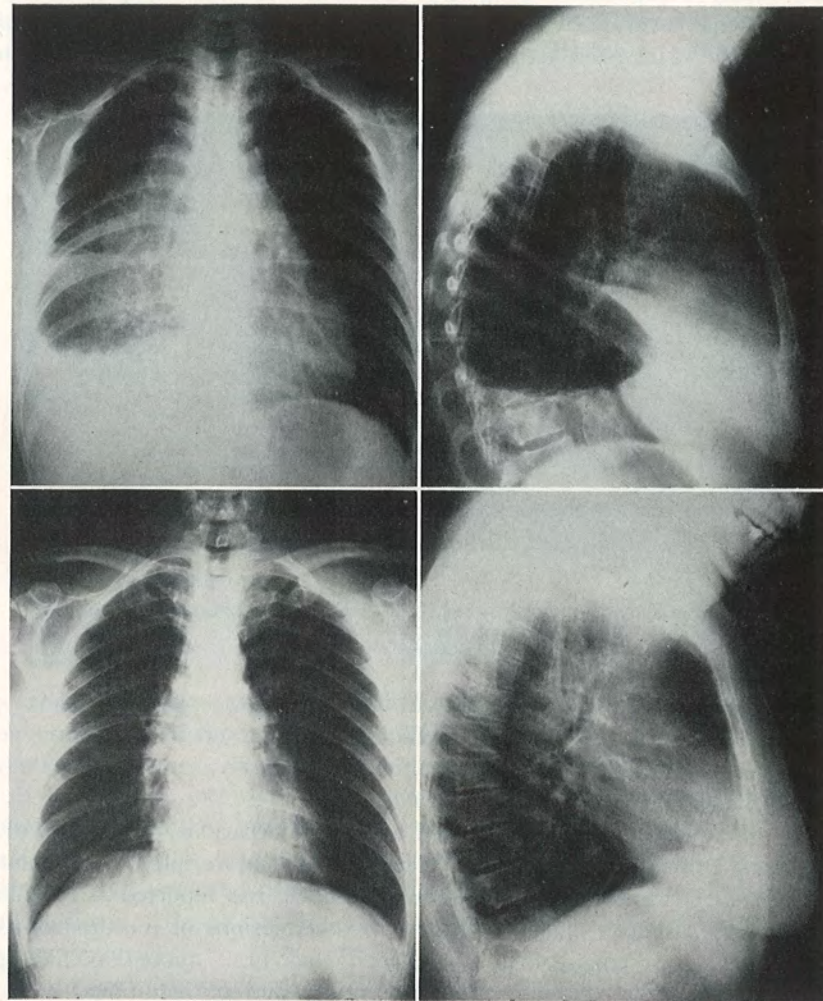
(Top) Hodgkin's disease involving right middle lobe and mediastinum and infiltrating the zone of the diaphragm. (Bottom) Same patient 16 months later, having responded well to x-ray therapy in small doses. The patient was followed for 11 years, with repeated recurrences of lymphadenopathy, again controlled by small doses of x-ray.
